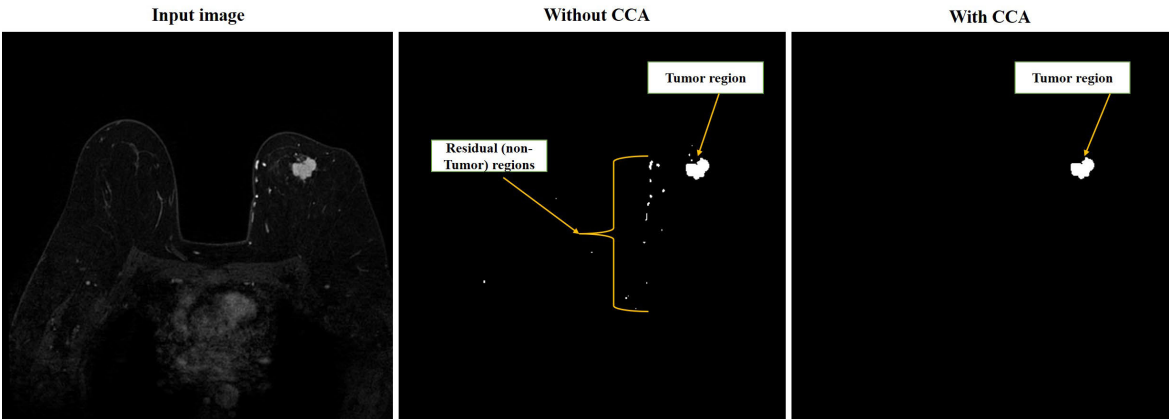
Representative DCE-MRI demonstrating the usage of CCA in the framework.
